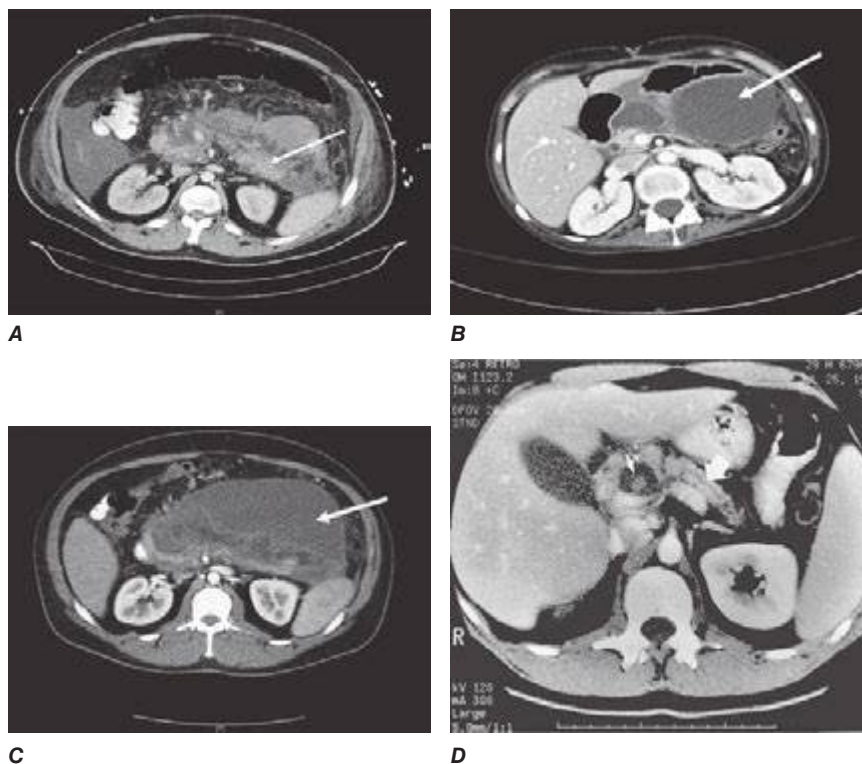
A. Acute necrotizing pancreatitis: computed tomography (CT) scan. Contrast-enhanced CT scan showing acute pancreatitis with necrosis. Arrow shows partially enhancing body/tail of pancreas surrounded by fluid with decreased enhancement in the neck/body of the pancreas. B. Acute fluid collection: CT scan. Contrast-enhanced CT scan showing fluid collection in the retroperitoneum (arrow) compressing the air-filled stomach arising from the pancreas in a patient with asparaginase-induced acute necrotizing pancreatitis. C. Walled-off pancreatic necrosis: CT scan. CT scan showing marked walled-off necrosis of the pancreas and peripancreatic area (arrow) in a patient with necrotizing pancreatitis. Addendum: In past years, both of these CT findings (Figs. 371-2B and 371-2C) would have been misinterpreted as pseudocysts. D. Spiral CT showing a pseudocyst (small arrow) with a pseudoaneurysm (light area in pseudocyst). Note the demonstration of the main pancreatic duct (big arrow), even though this duct is minimally dilated by endoscopic retrograde cholangiopancreatography. (A, B, C, courtesy of Dr. KJ Morteale, Brigham and Women's Hospital; D, courtesy of Dr. PR Ros, Brigham and Women's Hospital; with permission.)
